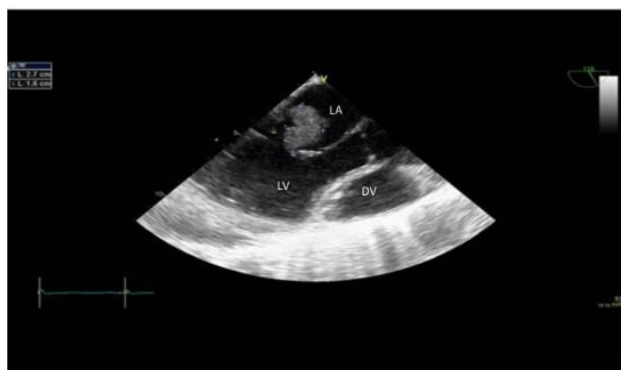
Transesophageal echocardiography showed large tumor mass 27 mm × 16 mm in cavum of left atrium.
